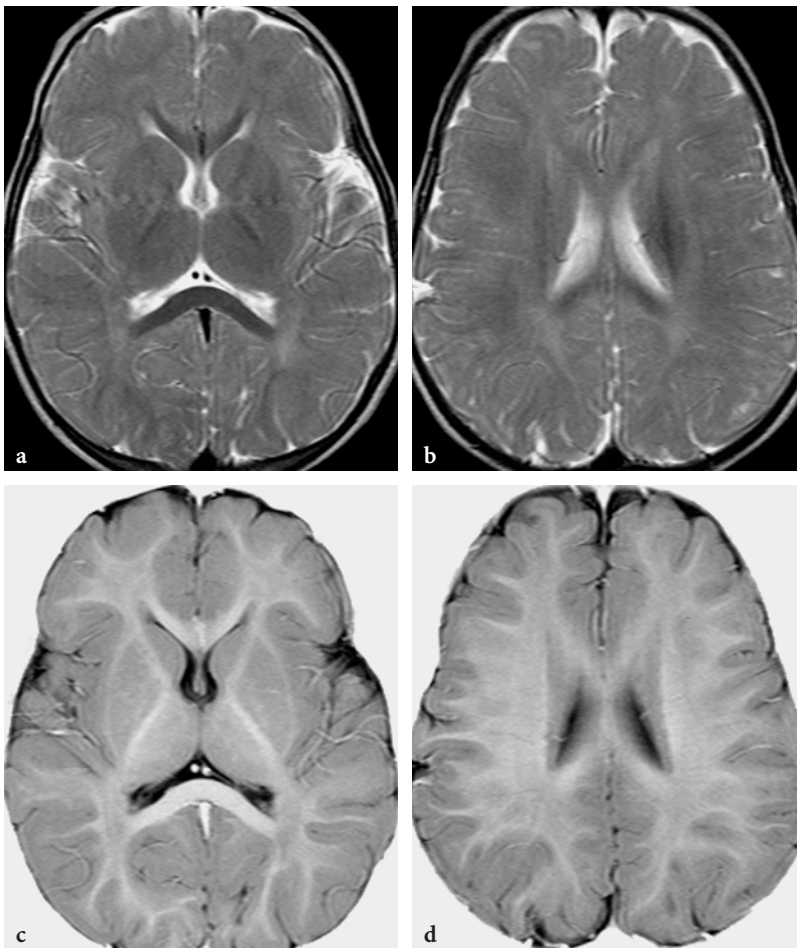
MR imaging findings in a 14-month-old male patient with treated isovaleric aciduria. a, b Axial T2-weighted fast spin-echo images at the level of the deep gray matter structures. No basal ganglia abnormality is seen (a). Diffuse paucity of the myelin within the cerebral hemispheres, mainly peripherally (note the dense myelin within the corpus callosum). Subtle signal inhomogeneities are seen within the centrum semiovale (b). c, d T1-weighted inversion recovery images. These images suggest some sparing of the subcortical U fibers, which suggests a demyelinating element in the white matter disease, in addition to hypo- and delayed myelination
